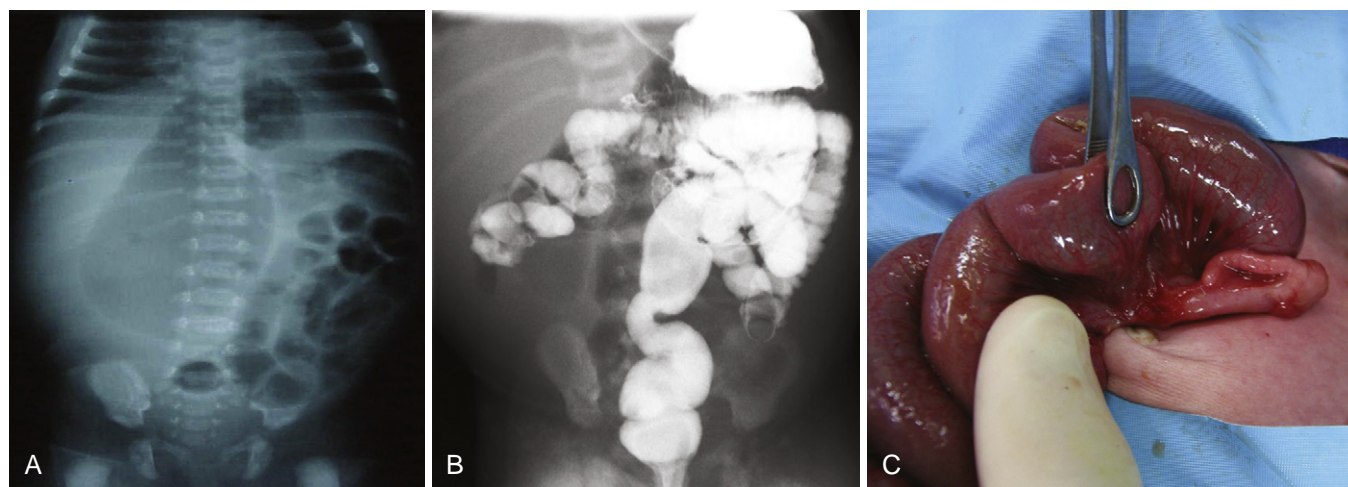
Ileal atresia. A, Radiograph of the abdomen showing dilated loops of intestine with a very distended loop inhabiting most of the right abdomen. B, Contrast enema showing a small colon that does not fill the dilated loops of bowel. C, Distal ileal atresia with the terminal ileum and cecum seen on the right side of the photograph.
